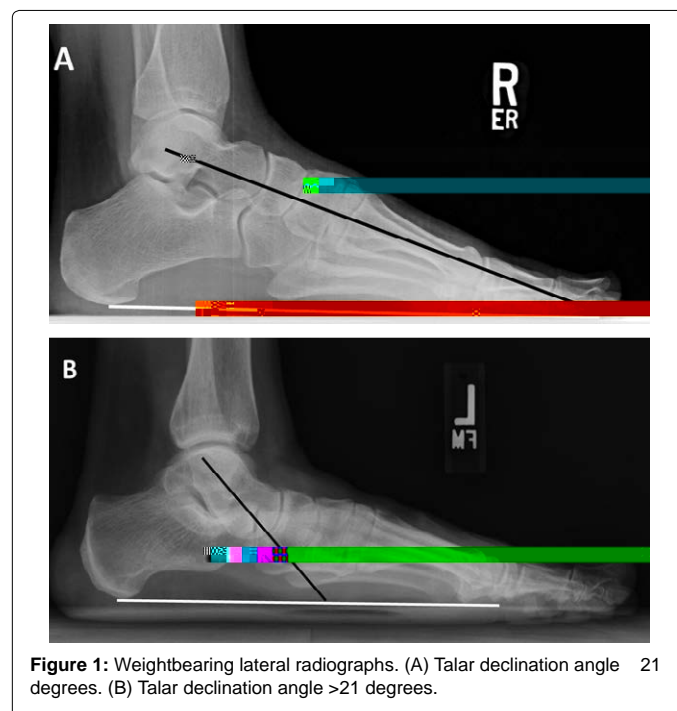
Weightbearing lateral radiographs. (A) Talar declination angle 21 degrees. (B) Talar declination angle >21 degrees.
